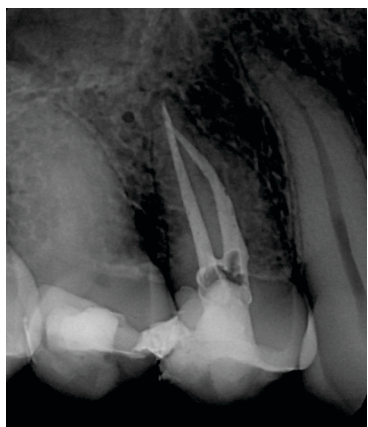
Post obturation radiograph after bypassing the fractured file
